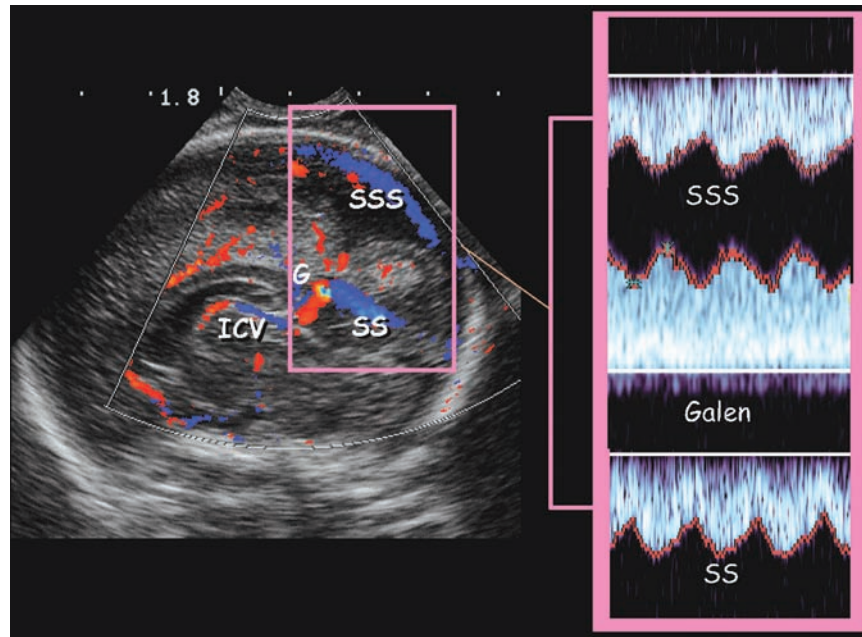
Normal cerebral venous circulation. (Left) Sagittal image of color Doppler. SSS, superior sagittal sinus; ICV, internal cerebral vein; G, vein of Galen; SS, straight sinus. (Right) Normal blood flow waveforms of dural sinuses. In normal fetuses, venous flow always has pulsations.
